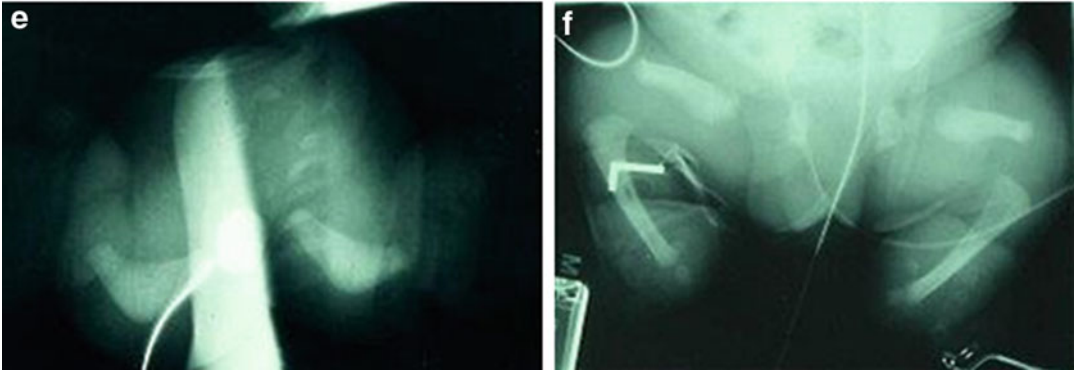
(a–f) A male infant with atelosteogenesis I/boomerang dysplasia. Prenatal ultrasound showed polyhydramnios and a short limb dwarf. The infant died at 57 days. He showed relatively large head, hypertelorism, depressed nasal bridge, midfacial hypoplasia, micrognathia, cleft palate, short neck, relatively narrow chest, protuberant abdomen, severe “rhizomelic” micromelia, absent elbow joints, genu varus, and talipes equinovarus. Radiographic features included unossified
